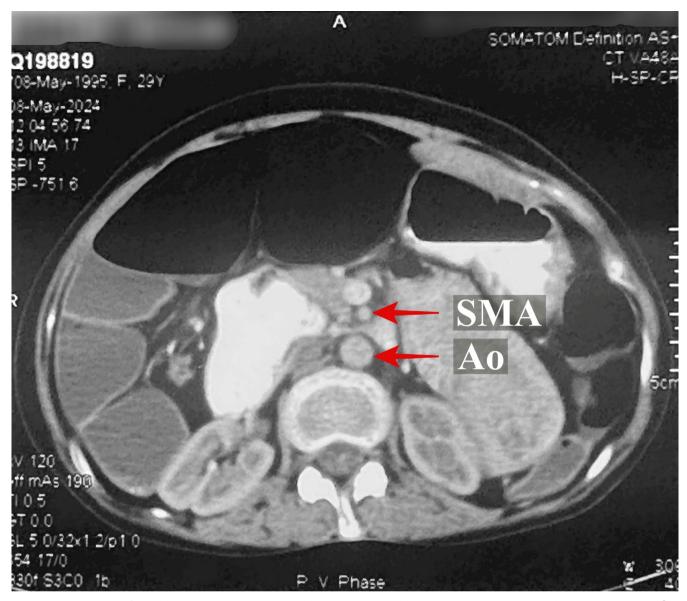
CT scan of the abdomen shows the entrapped duodenum between the superior mesenteric artery and the abdominal aorta. [Ao, Aorta; SMA, Superior Mesenteric Artery].
